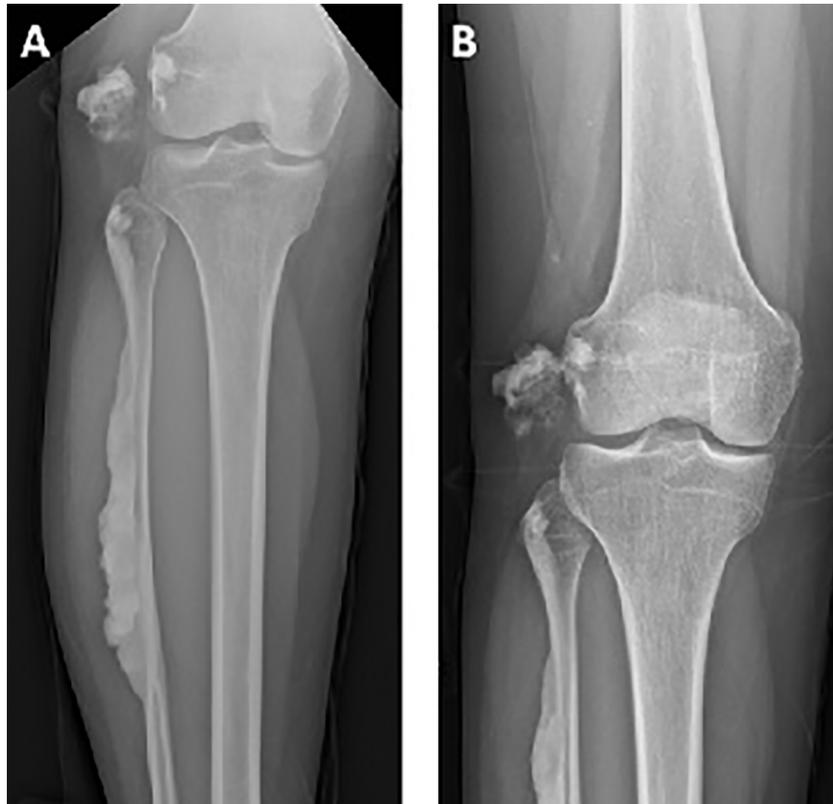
A and B Frontal radiographs of the right tibia and fibula (A) and knee (B) demonstrate the classic “candle wax” cortical hyperostotic lesions along the right fibula and lateral femoral condyle. Myositis ossificans-like soft tissue ossifications are seen lateral to the lateral femoral condyle.
